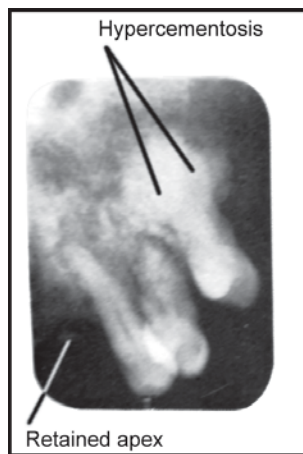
IOPA radiograph showing hypercementosis-Pagets disease
